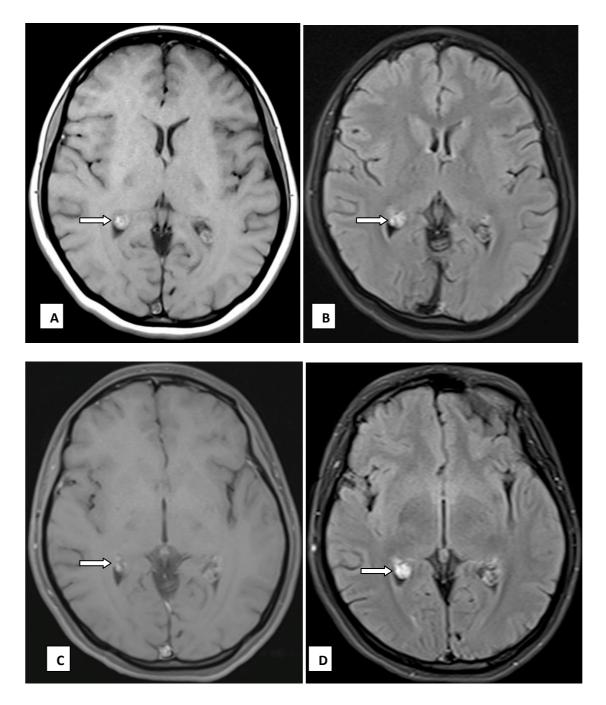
A 20-year-old female diagnosed with choroid plexus xanthogranuloma. MRI Brain axial sections (A) T1WI & (B) T2 FLAIR shows heterogeneously hyperintense lesion in occipital horn of right lateral ventricle. This lesion demonstrates mild enhancement on (C) T1 FS PC image & avid enhancement on (D) T2 FLAIR PC image.
